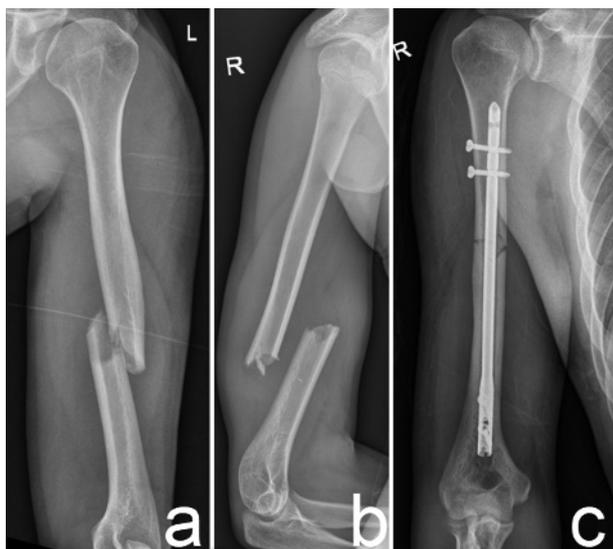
Radiographs a) AO 12-A2 fracture ; b) AO 12-A3 fracture ; c) Postoperative radiograph after treatment with a retrograde intramedullary nail.
